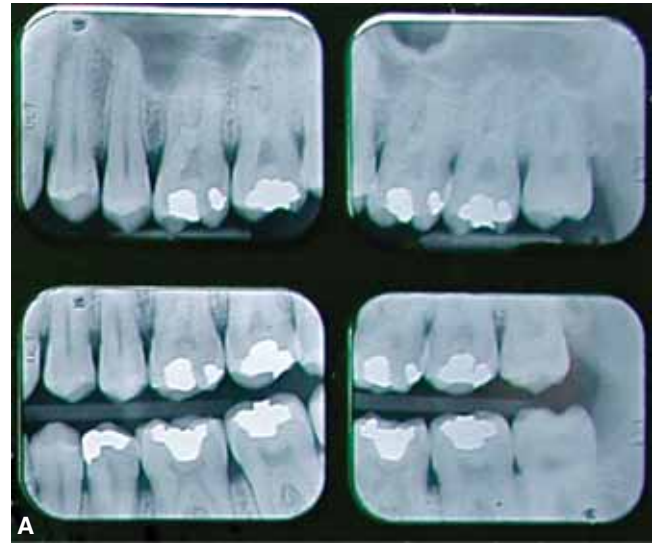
Comparison of antemortem and postmortem radiographs looking for similarities of restorations and general morphology. A. Antemortem radiographs of the same victim shown in *Figure 12-1* demonstrate multiple dental restorations, unique root and sinus morphology, pulp chamber shape, interdental bone height, and trabecular patterns. B. Postmortem radiographs show consistency in some restorations when compared to the antemortem radiographs, but note that several teeth have had restorations placed after the antemortem radiographs were obtained. For example, an MOA was placed on tooth No. 13, a crown was placed on tooth No. 19, an MOA on tooth No. 20 was replaced with a MODA, and third molars numbers 16 and 17 were extracted. Also noted are identical matching restorations that had not been replaced, as well as the unique root and sinus morphology, pulp chamber shape interdental bone height, and trabecular patterns. This was sufficient to prove positive identification of this individual.
